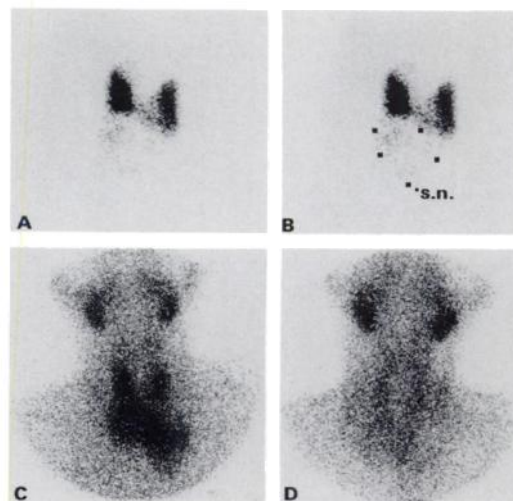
Technetium-99m and ^{201}Tl thyroid scintigraphy in a 34-yr-old female. A cold nodule in the right lower lobe and isthmus is visualized (A,B, s.n.-sternal notch). An increased ^{201}Tl uptake is demonstrated in the nodule in the early (15 min, C) image. It includes a large retrosternal portion which could not be appreciated on the $^{99\text{m}}\text{Tc}$ image. The late image (3 hr, D), demonstrates complete washout of ^{201}Tl . The visual score was +1 and 0, and the L/N 0.95 and 0.75 respectively. The diagnosis was colloid nodule.
